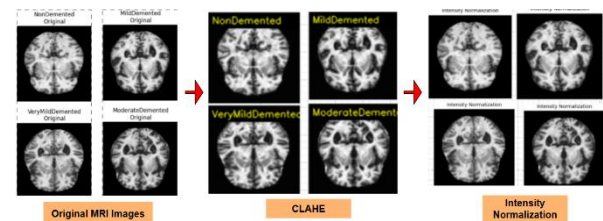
MRI images pre-processing by using CLAHE and intensity normalization.
